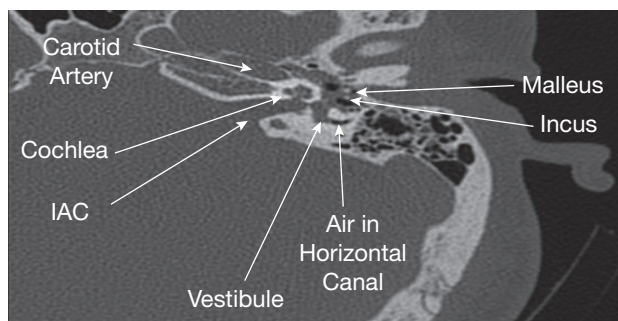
The axial CT of our patient's temporal bone demonstrates air (black) within the horizontal semicircular canal. Fluid within the inner ear appears gray gray. "IAC" stands for "internal auditory canal."
